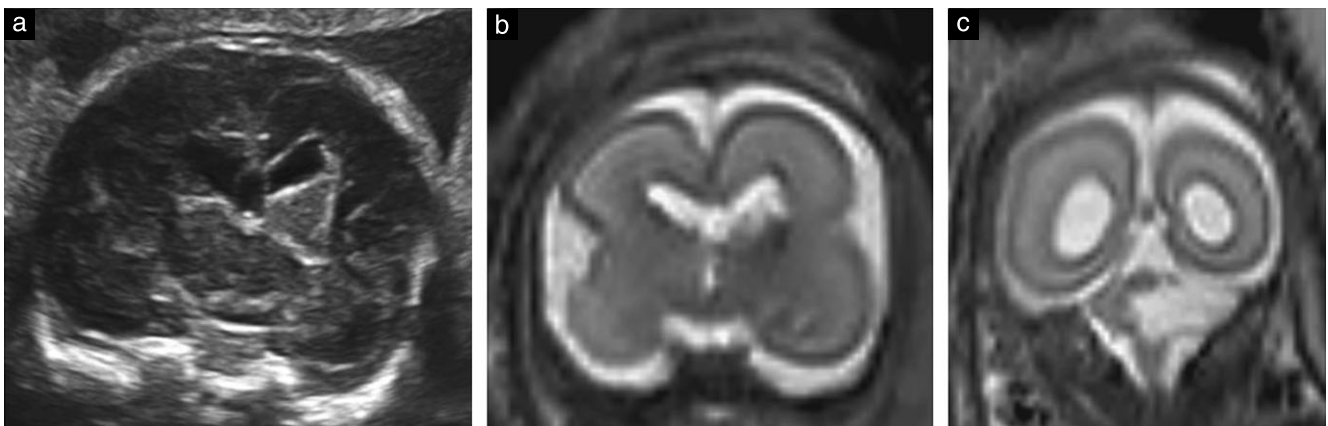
(a) Prenatal coronal ultrasound image at 21 + 6 weeks' gestation showing a wedge-shaped echogenic lesion of the thalamus adjacent to the left lateral ventricle. (b) Prenatal coronal T2SE-weighted magnetic resonance image (MRI) at 23 + 4 weeks' gestation, confirming the lesion and showing a low-signal-intensity area at the border, suggestive of a hemorrhagic component. (c) Prenatal MRI at 23 + 4 weeks' gestation, showing the absent left cerebellar hemisphere on posterior coronal view.
